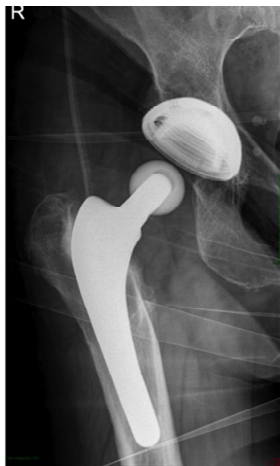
Radiograph of the dislocated THA.
